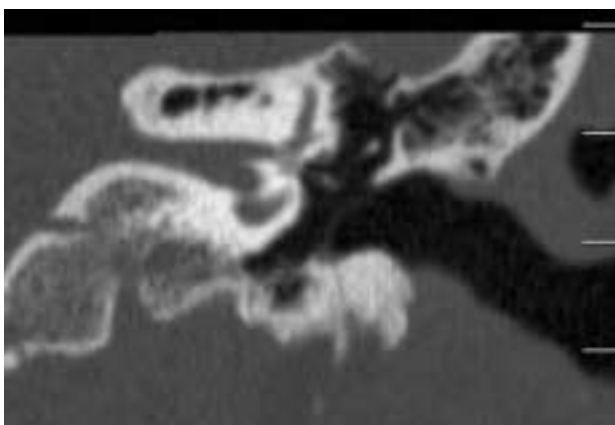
Pre operative CT-scan Pat.3239232
